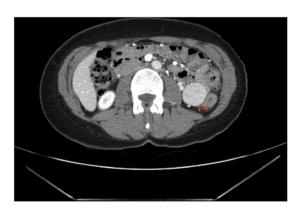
Abdominal contrast-enhanced computed tomography: $32 \times 32 \times 34$ mm homogeneus hypervascular well-defined solid tumor with a small central hypodensity (red arrow) located in the intraperitoneal left posterior abdominal void, with an apparent intraperitoneal location. The dependency organ is not defined, only broad contact is seen with adjacent intestinal loops but without thickening or stenosing them.
